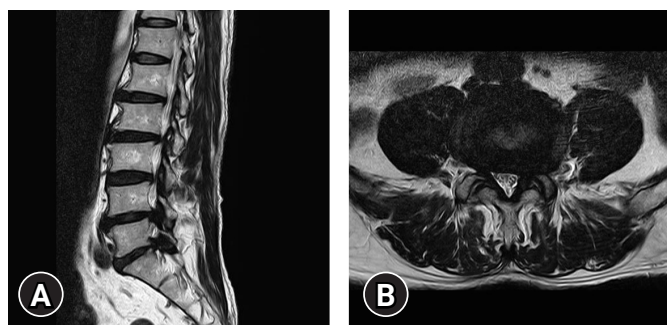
(A) Sagittal T2-weighted magnetic resonance image (MRI) showing left foraminal stenosis at L4-5 level. (B) Axial T2-weighted MRI showing left foraminal stenosis at L4-5 level.
